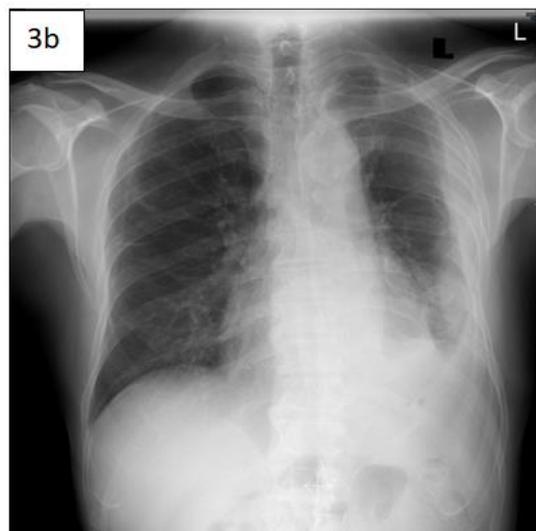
Post operative chest x-ray demonstrating well expanded lung with residual opacification over the left lower lobe
